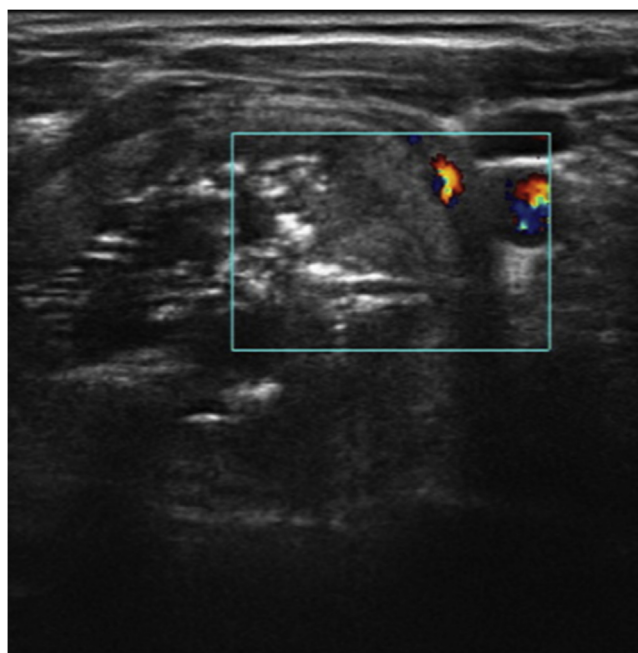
Color-coded Ultrasound image of the nodule before cooled Microwave ablation treatment showing intranodular blood flow.
